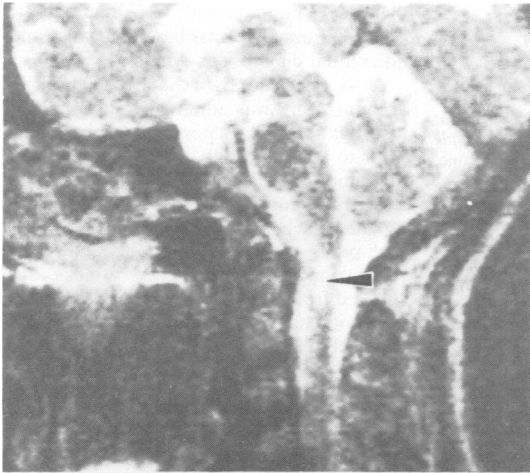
Fig MRI of the spinal cord in the sagittal plane, recorded with a Phillips Gyroscan (a magnetic field strength of 0,5 Tesla) using a spin-echo pulse sequence (echo-time 50 ms). The lesion in the cervical medullar parenchyma is at the level of C2 (arrow = light area)
